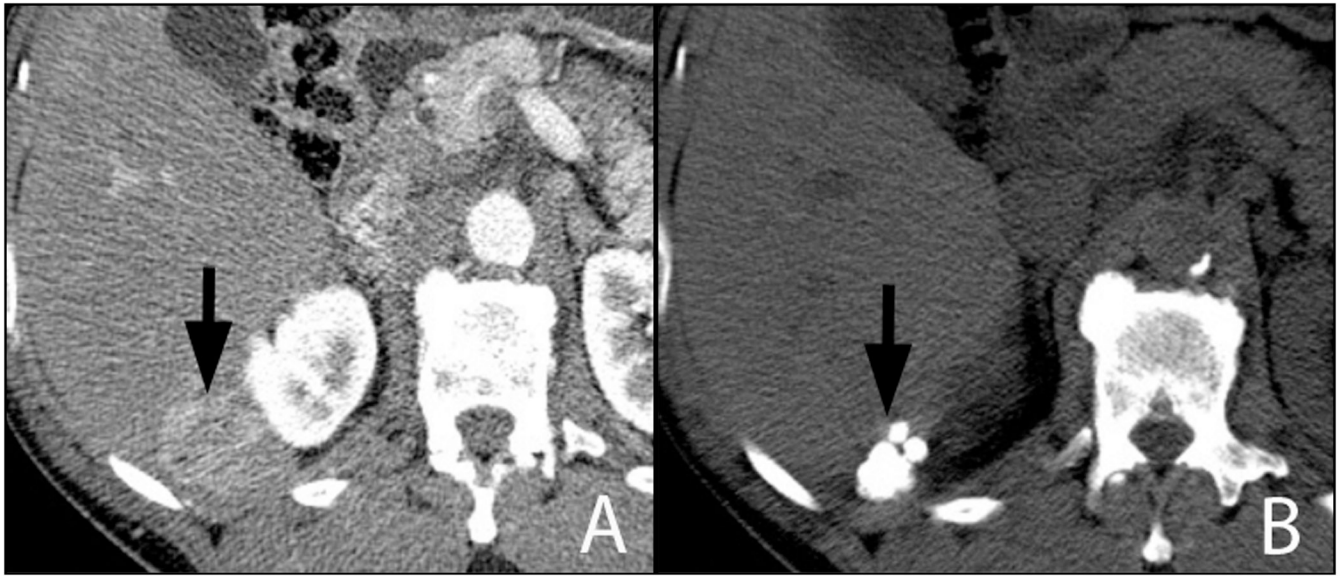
Contrast-enhanced CT of the liver during arterial phase of imaging shows a hypervascular mass (A, arrow) adjacent to the right kidney. Repeat CT performed 3 months following TACE demonstrates extensive uptake of ethiodized oil and no residual enhancement within the lesion (B, arrow). This lesion was found to be 100% necrotic at pathology.
